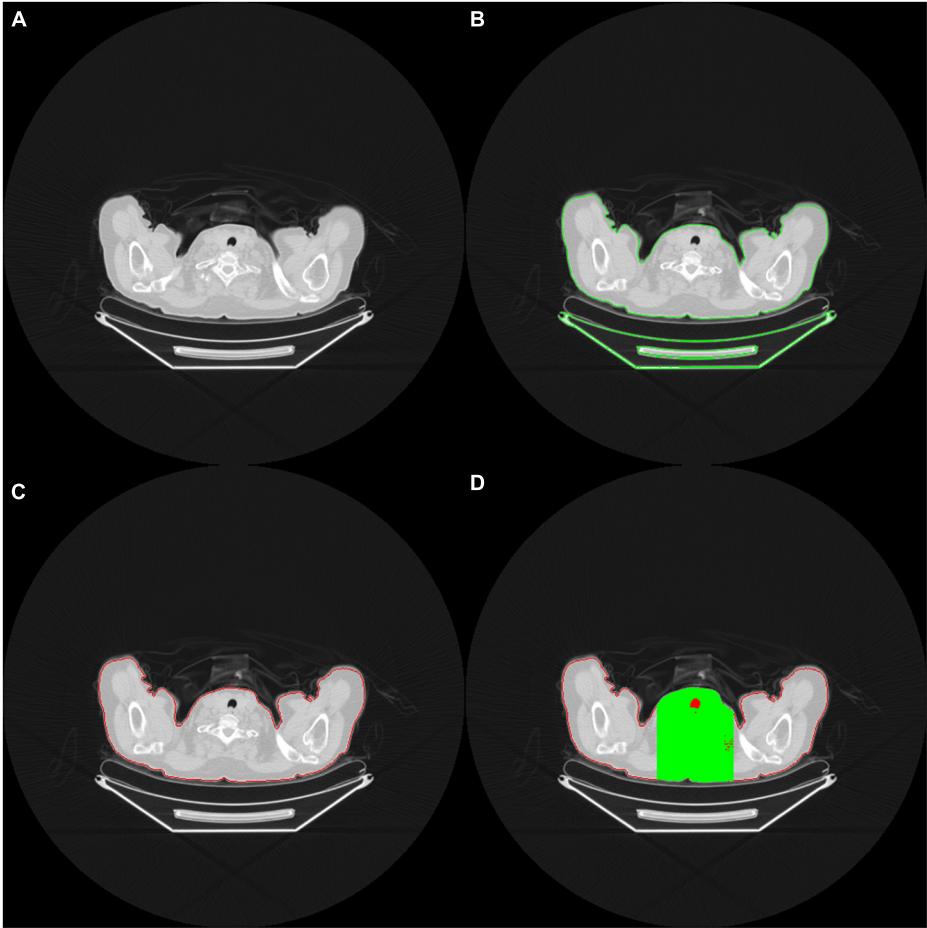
(A) The red contour delineates the air (black area) within the tracheal lumen, which helps the program determine the upper edge of the lungs (B) OpenCV identifies the contour area of the body on the CT images (C) Body contour block (red contour block) (D) Green area indicates the limited calculation area. Only the black area in the green range is included in the calculation of the ratio.
